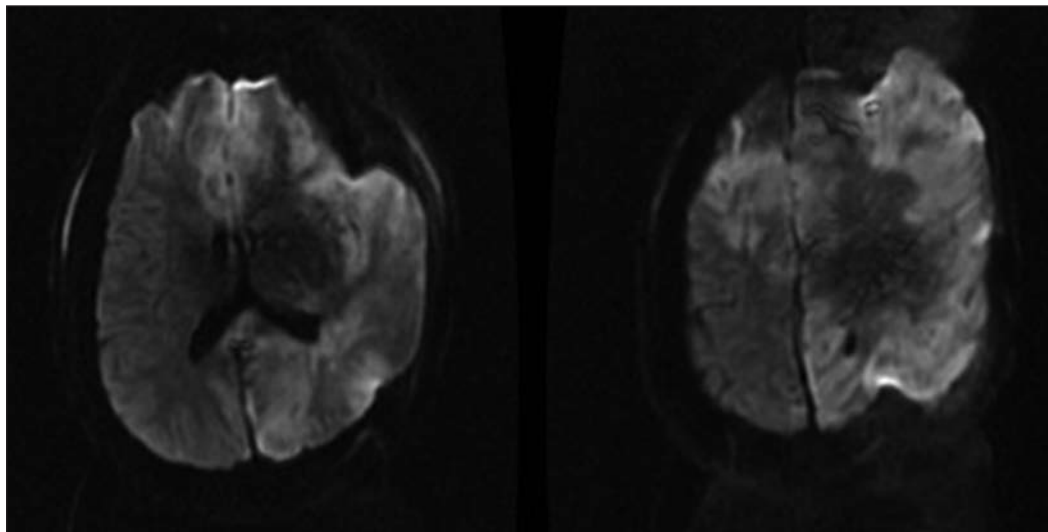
DWI at inferior (left) and superior (right) of craniectomy site demonstrating hyperintensity at bony edges, suggestive of restricted diffusion, and ischemia.
